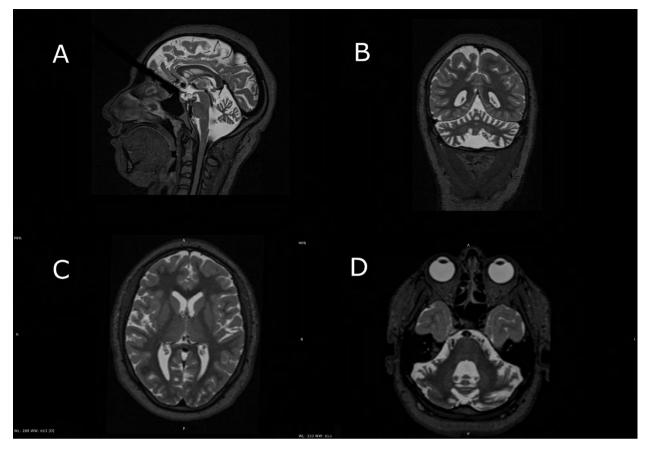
Brain MR imaging findings in 15-year-old female patient with pathogenic PNKP-gene mutation and ataxia-oculomotor apraxia; sagittal (A), coronal (B) and axial (C, D) multiplanar reconstructions of 3D T2-weighted images show global and extensive cerebellar volume loss, involving both vermis and cerebellar hemispheres (A, B, C), along with moderate volume reduction of both middle cerebellar peduncles (C) and subsequent enlargement of fourth ventricle. (A, B, C). Furthermore, axial image at level of gangliocapsular region (C) reveals microcephaly without clearly abnormal gyral pattern or other associated structural abnormalities
